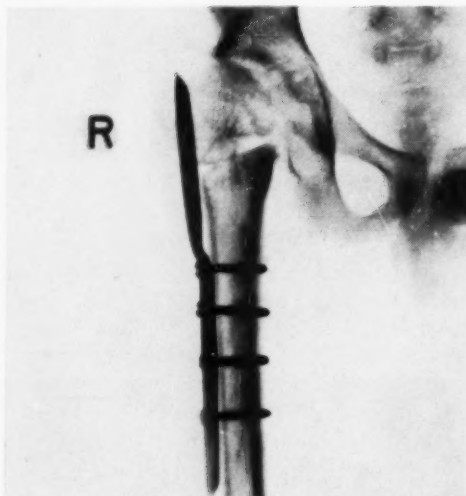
Roentgenogram of the right hip of the same patient as in Figures 11 and 12 immediately following a McMurray displacement osteotomy, held with a blade plate. This roentgenogram was taken seven weeks after Fig. 12.
